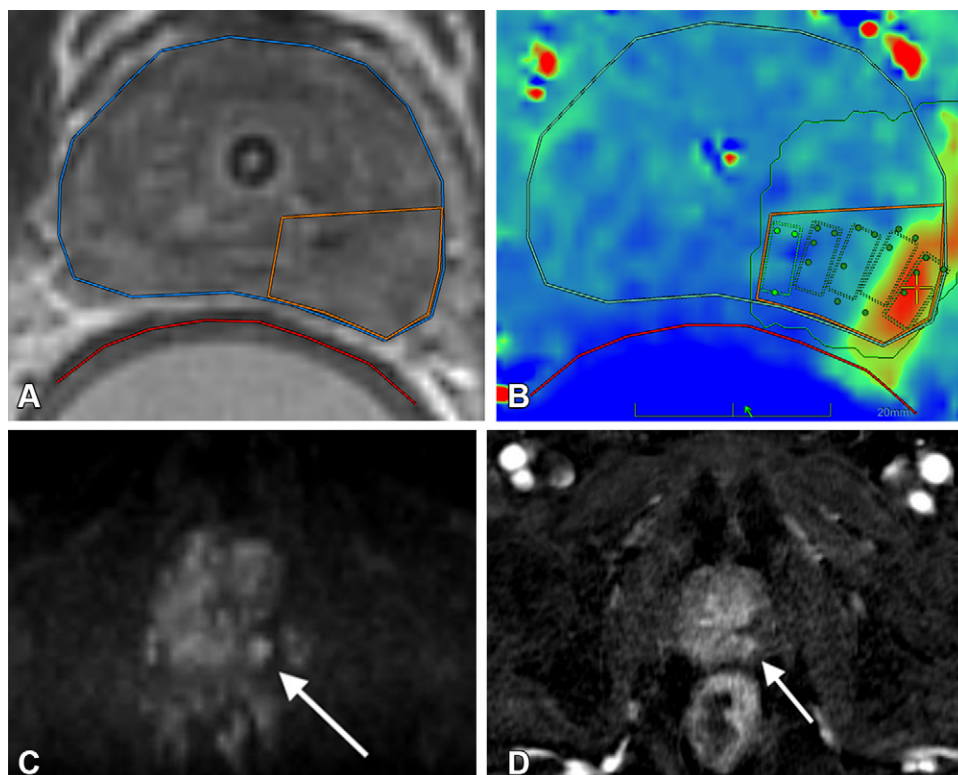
MRI-guided focused ultrasound (MRgFUS) for grade group 3 prostatic adenocarcinoma. (A) Axial MRI scan obtained during transrectal-approach MRgFUS ablation shows the rectal wall (red), prostate margin (blue), and the region of interest for treatment (orange). (B) Map from MRI thermometry obtained during treatment depicts the temperature, with heat deposition color coded. The hottest to coldest temperatures are shown in red, orange, yellow, green, and blue. Heat deposition is color coded, with red indicating the hottest temperatures and blue indicating the coldest temperatures. Rectangles represent nominal sonication spots, and dots represent each of the prescribed focal points. (C, D) At 24 months after ablation, there are imaging findings suspicious for recurrent disease (arrow) at the medial aspect of the ablation zone, including (C) focal hyperintensity on axial diffusion-weighted MRI scan, with (D) associated early enhancement on axial dynamic contrast-enhanced image. Targeted biopsy of the suspicious area in the treatment zone was positive for disease recurrence, and the patient subsequently underwent salvage radiation therapy.
